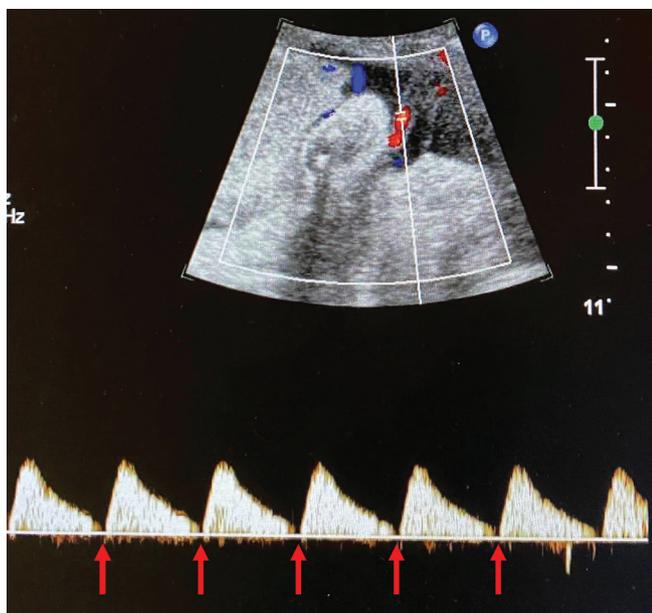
Doppler ultrasonogram of a 28-year-old woman at 35 + 5 weeks' gestational age showing absent end-diastolic flow velocity (arrow) in the umbilical arteries.
